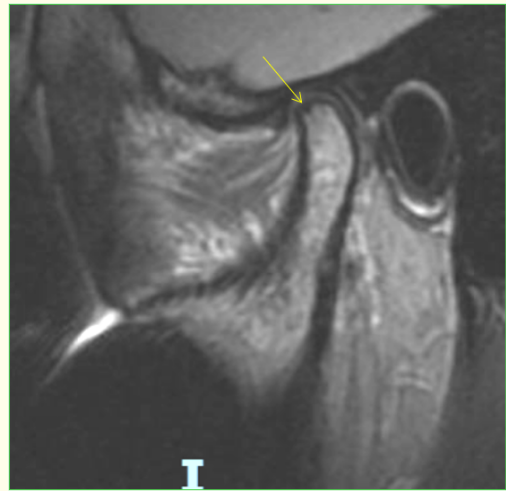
MRI of the right TMJ on sagittal view. Incipient alteration of the right condyle cartilage on its superior-anterior aspect. *Yellow arrow:* presence of subchondral cyst in the right condyle, a characteristic sign of developing osteoarthritis in the right TMJ.
